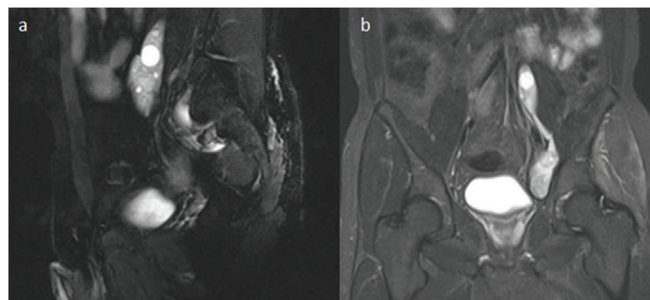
a. Sagittal T2W fat saturated abdominal MR image. A mass lesion at the medial side of the psoas muscle is extending down along the lateral pelvic wall, encompassing the psoas muscle at its superior part anteriorly and posteriorly, and contains multiple cystic components. b. Coronal T2W fat saturated abdominal MR image. In the left paravertebral area, a mass lesion with regular borders of approximately 14x2.5 cm dimensions, starting from the level of the corpus of the L4 vertebra, at the medial side of the psoas muscle extending down to the acetabulum level.
